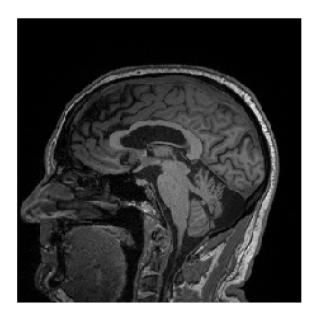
Dense Net MRI image
